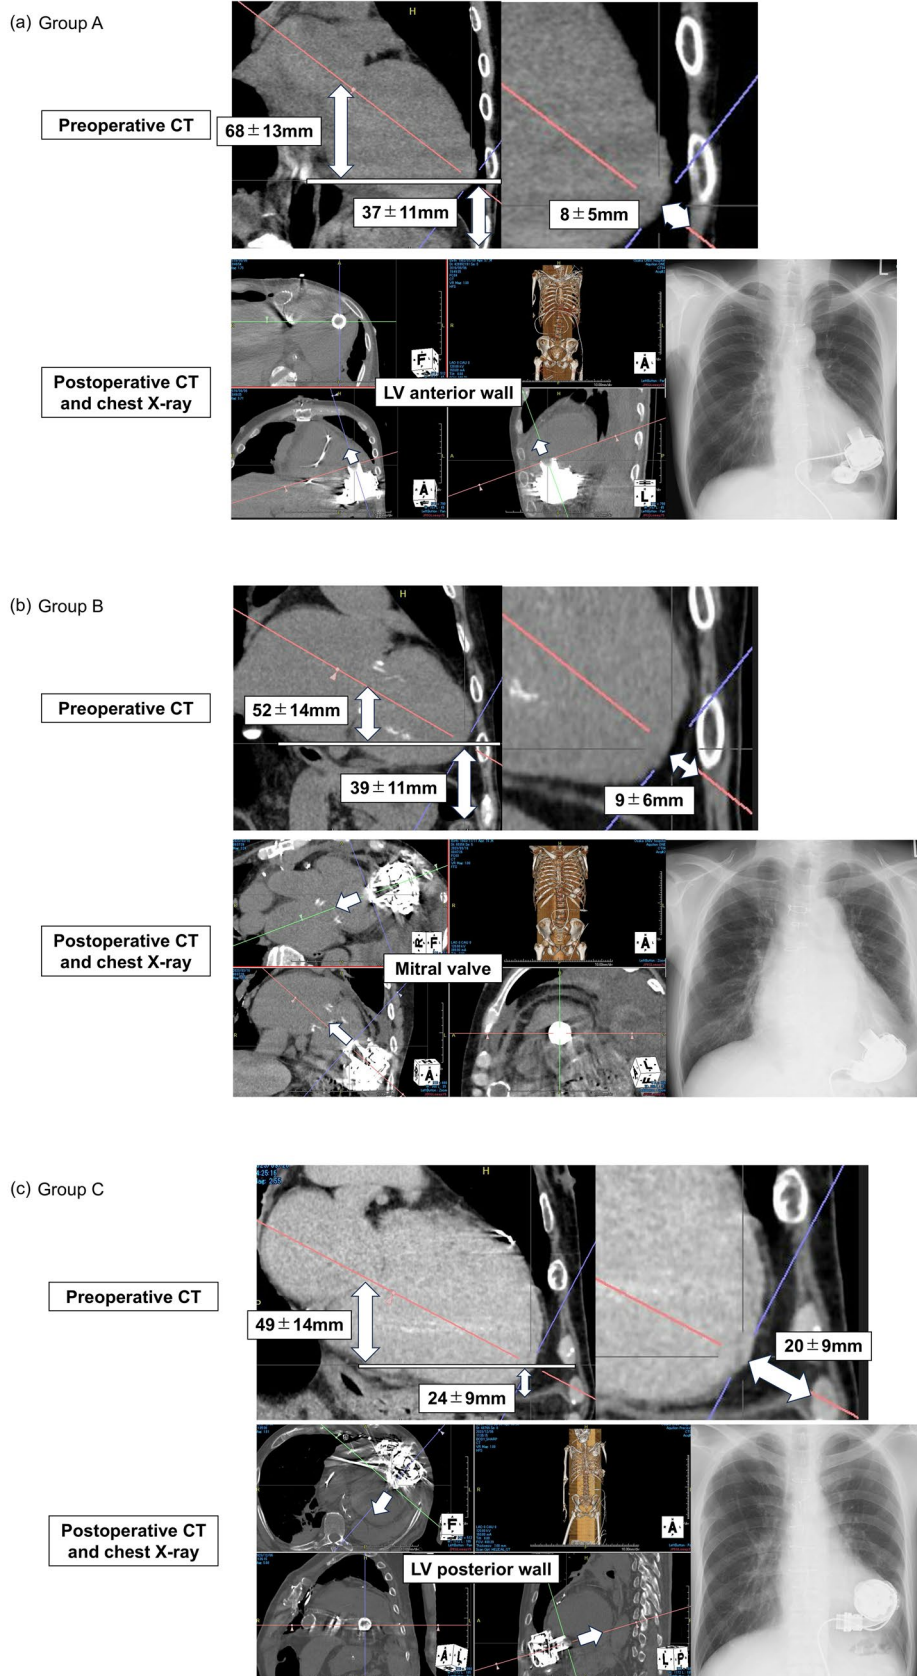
Parameters measured on preoperative CT in terms of the direction of the IC. (a) Images of a patient with the IC directed toward the LV anterior wall, (b) images of a patient with the IC directed toward the mitral valve, and (c) images of a patient with the IC directed toward the LV posterior wall. CT, computer tomography; IC, inflow cannula; LV, left ventricle.
